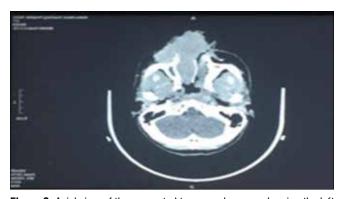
Axial view of the computed tomography scan showing the left nasal mass
